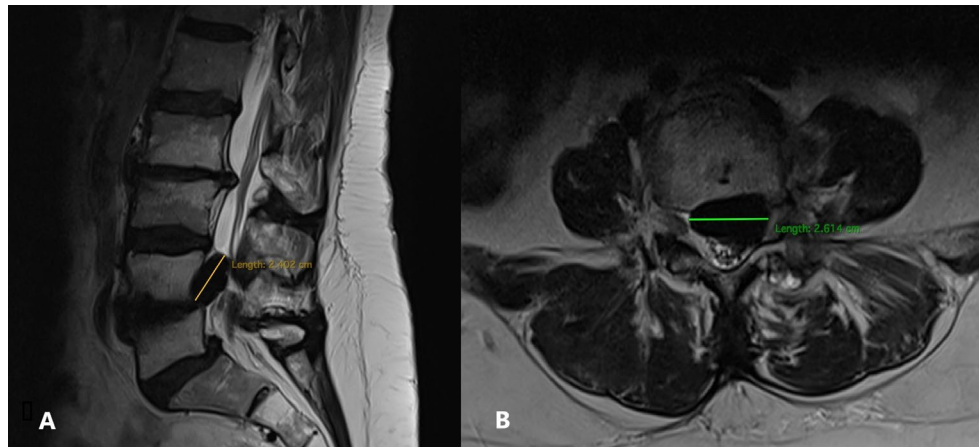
Preoperative coronal (A) and axial (B) views of MRI scan. The dimensions of the giant disc herniation at L4, L5 in these views.
